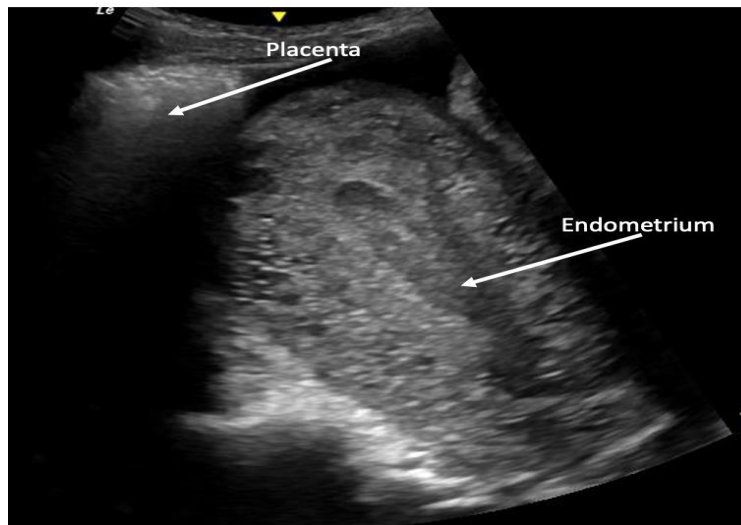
Ultrasound image of an empty normal-sized anteverted uterus with placenta attached to the uterine fundus.
